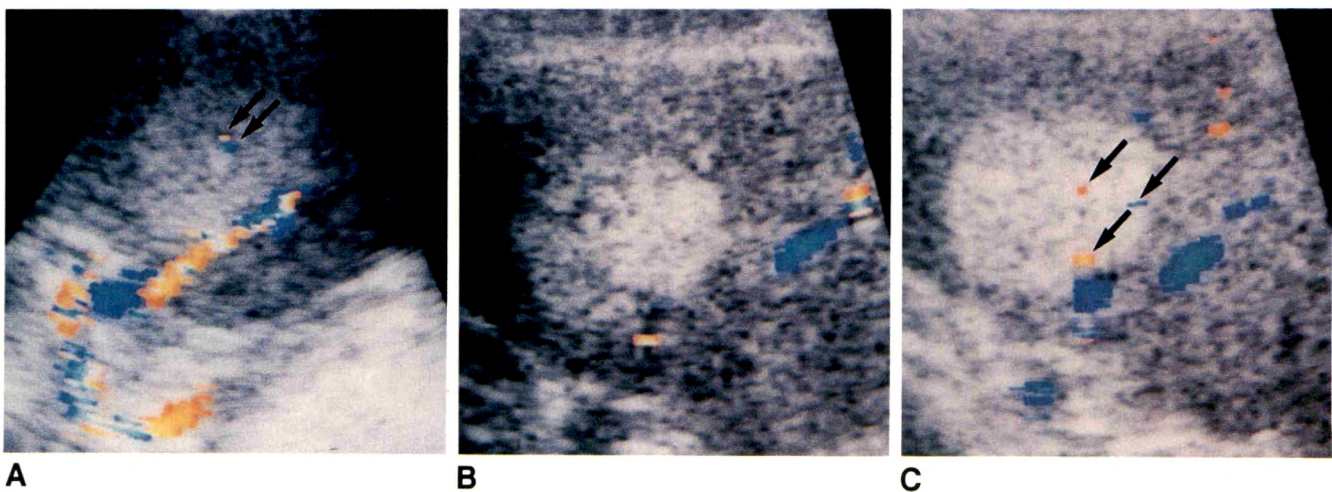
A, Color Doppler sonogram of spleen obtained without compression. Artery at periphery of tumor and a few color echoes in mass, indicative of blood flow within lesion (arrows), are shown.
